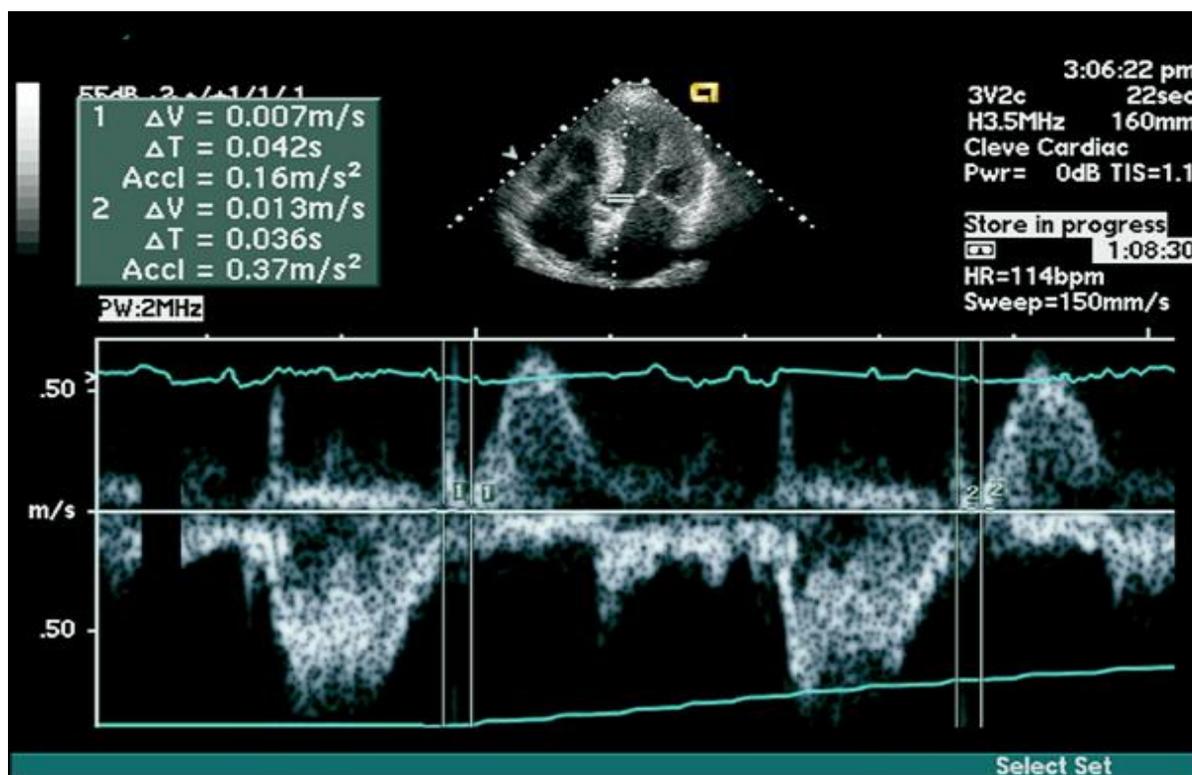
ECHOCARDIOGRAPHIC IMAGE OF A PATIENT WITH DIABETIC CARDIOMYOPATHY WITH VENTRICULAR HYPERTROPHY
